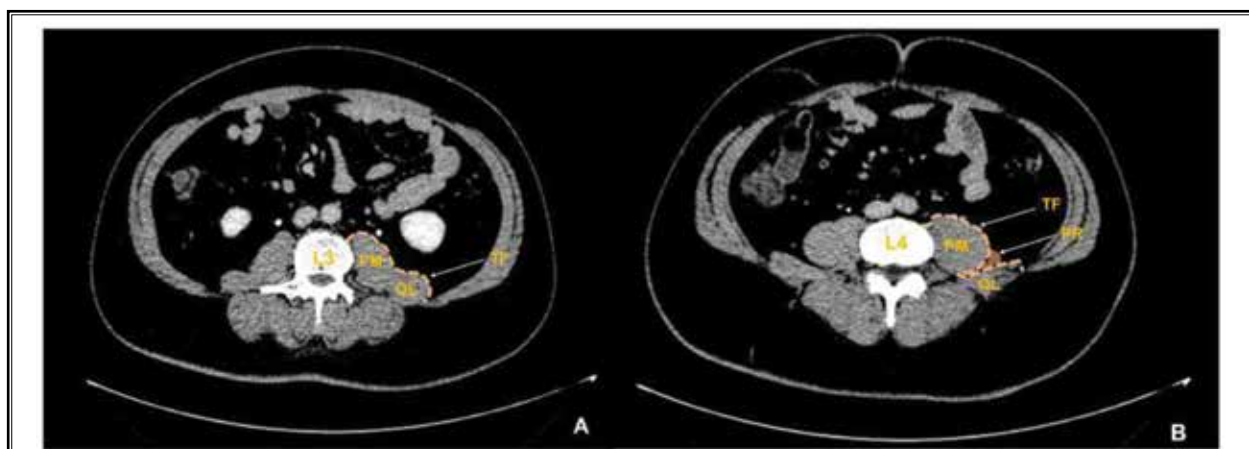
The cross-sections of CT images of the relations between the QL and PM muscles. (A) The cross-section of the L3 transverse process displays the overlap between the QL and PM muscles. (B) The cross-section of the L4 transverse process displays the separation of the QL and PM muscles. The potential recess appears between the QL and PM muscles. QL, quadratus lumborum; PM, psoas major; TF, transversalis fascia; PR, potential recess.
